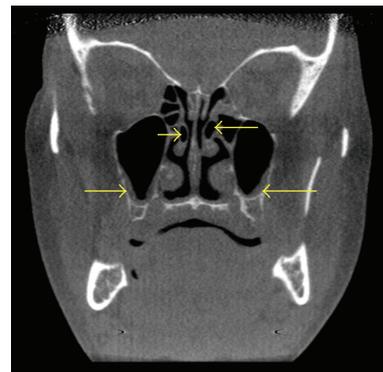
Coronal CT scan demonstrating bilateral middle concha bullosa (superior arrows) in combination with bilateral maxillary sinusitis (inferior arrows). Note the left concha bullosa (right superior arrow) is located slightly superior to the left concha. There is similar degree of sinus inflammation in both maxillary sinuses.
